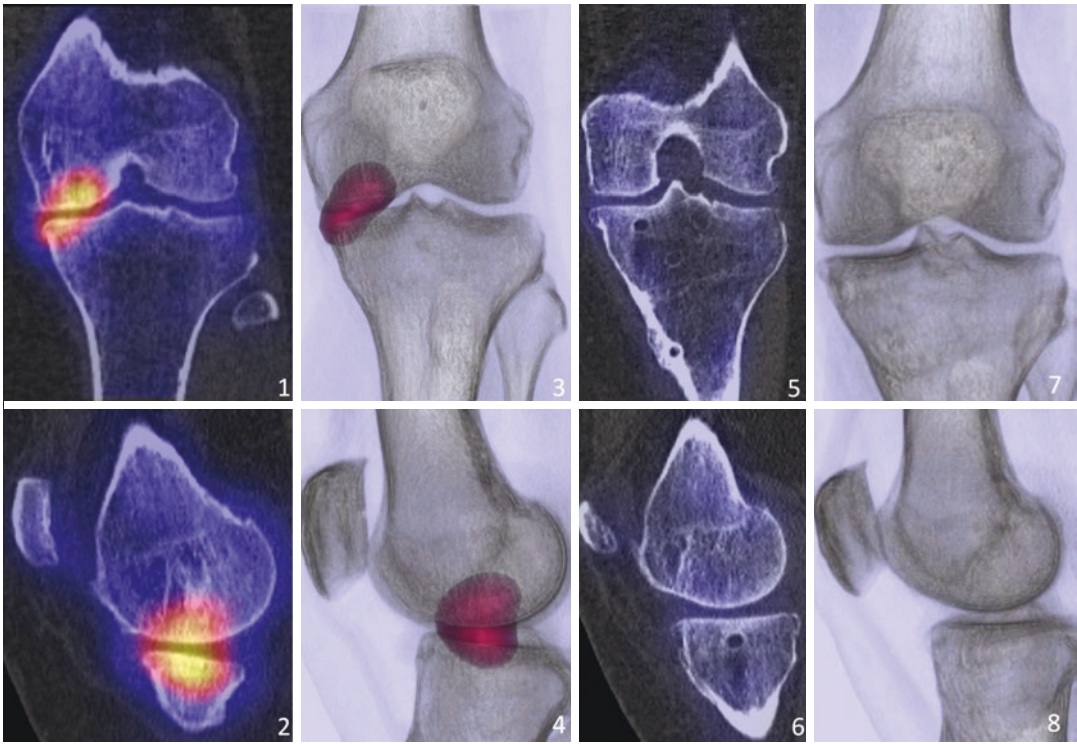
Left SPECT/CT images (1, 2) and 3D radiolucent reconstructions (3, 4) of a 52-year-old female patient before HTO showing medial overloading. Right SPECT/CT images (5, 6) and 3D reconstructions (7, 8) 16 months
